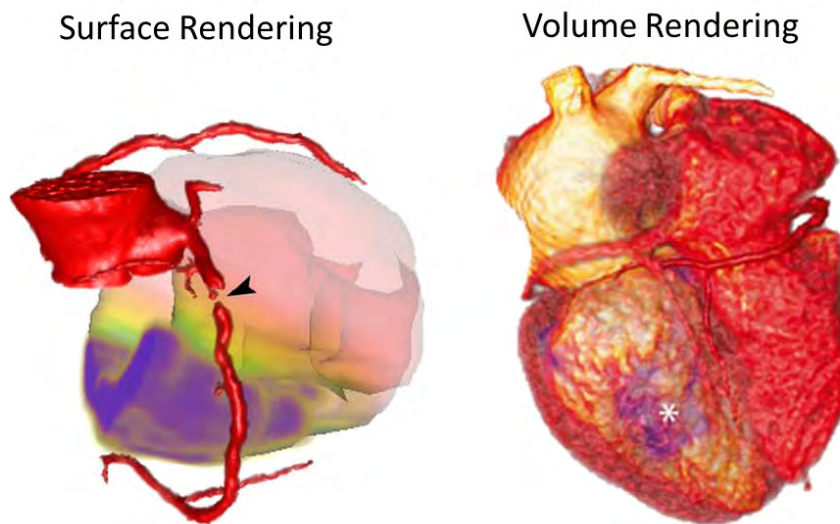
Fused CT and MRI visualizations. The left image shows the coronary tree segmentation from CTCA and the left ventricle extracted from the MR late enhancement as surface renderings. The colors of the ventricle surface indicates the distance from the infarction and thus its transmural. The right image shows a tagged volume rendering of the fused CTCA dataset and the segmented underperfusion. The CTCA is shown with a typical look-up-table whereas the perfusion defect is shown in blue.
